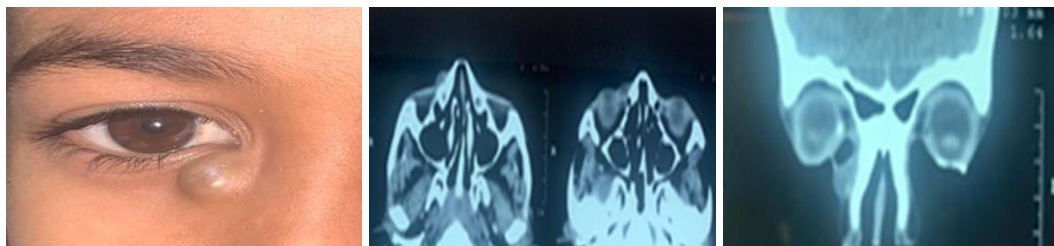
case-4-epidermal inclusion cyst- (CT drop-DCG showing pooling of dye in proximal part of sac, indicating pressure effect of the lesion on sac)
